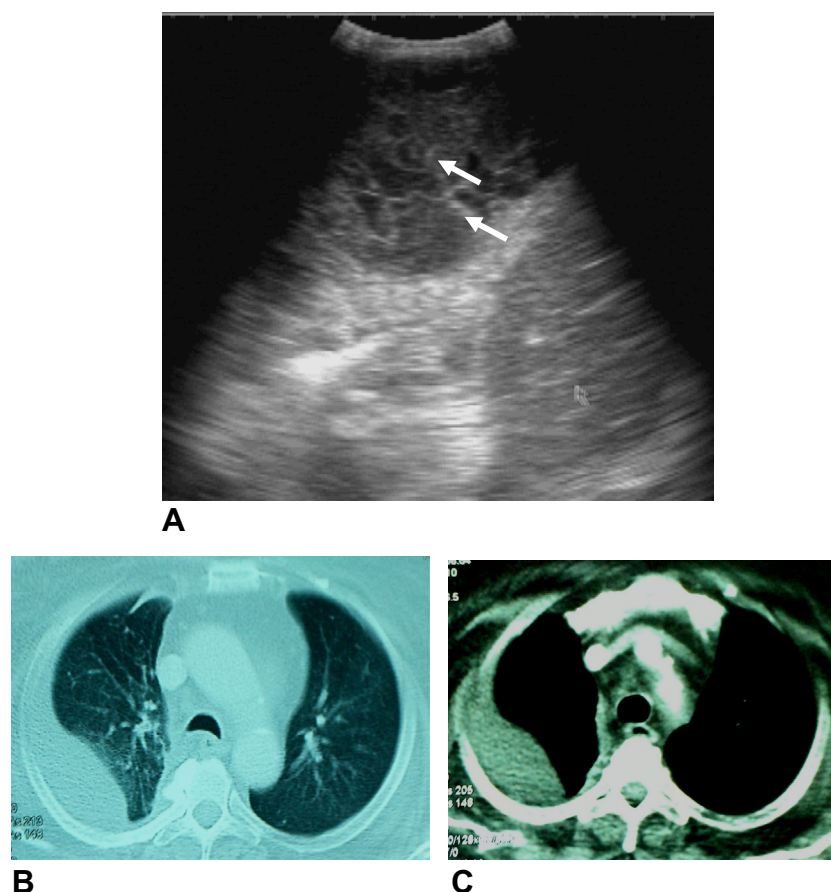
(A) Chest US image in B-mode shows moderate amount of highly echogenic right-sided encysted pleural effusion with fine internal septations (arrowed). (B and C) Postcontrast chest CT images in lung (B) and mediastinal (C) window settings display moderate amount of right-sided encysted pleural effusion, however, the fine septations seen by chest US were not evident by CT.
